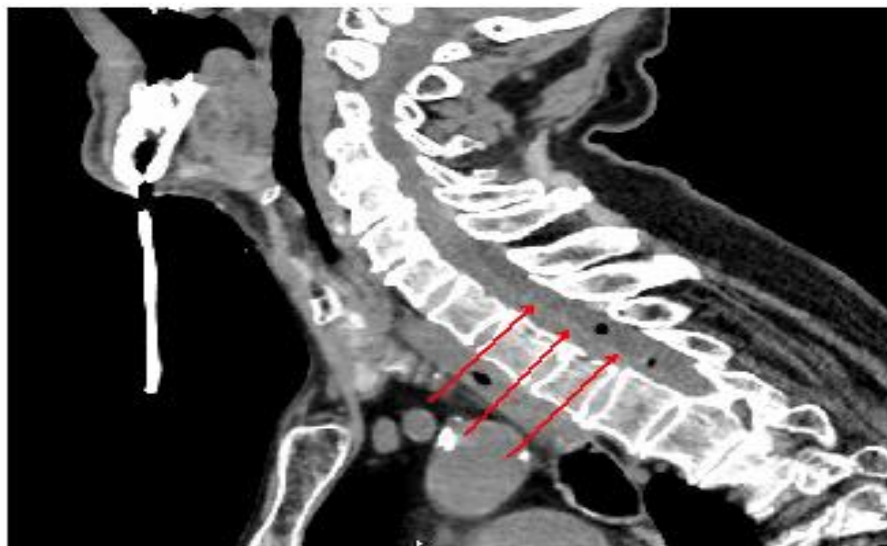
CT scan of the thoracic spine with fluid collection extending throughout the dorsal surface of the cervical and thoracic spinal cord (red arrows).
